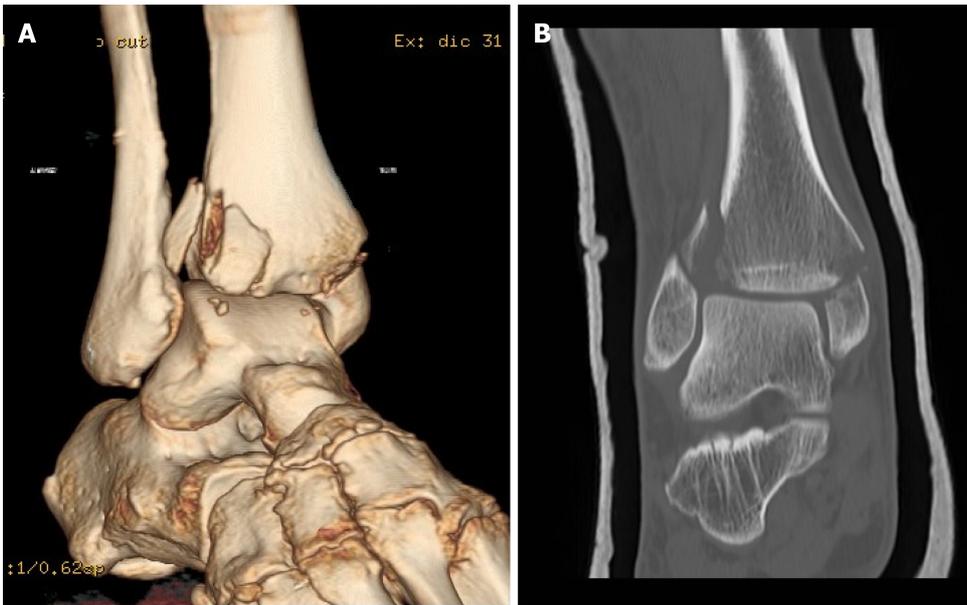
Computed tomography scans shows the involvement of the Tillaux-Chaput fragment. A and B: Tillaux-Chaput fragment.
